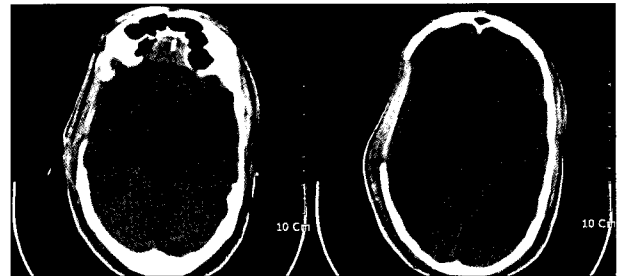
Brain computed tomography taken three months after decompressive craniectomy reveals that there are no hemorrhages at the previous operation site and posterior fossa.
